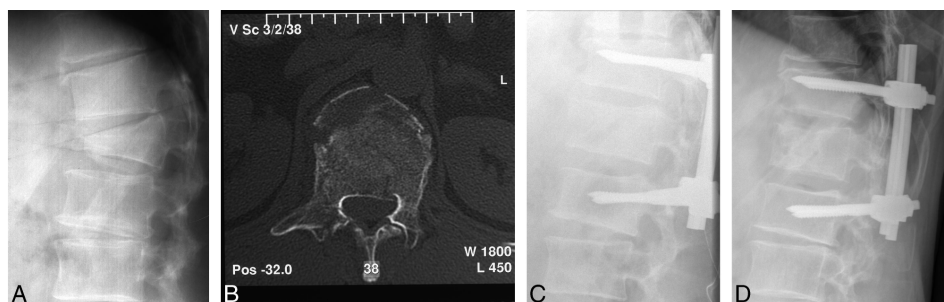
Patient with Type B.1.2 type fracture of L1 discovered during operation. Because of the posterior ligamentous injury, no instrumentation removal was performed. At final follow-up, this patient had a VAS Spine Score of 90 and a RMDQ-24 of 2. (A) Lateral radiograph on admission; (B) CT on admission; (C) Postoperative; (D) Final follow-up after 38 months.
